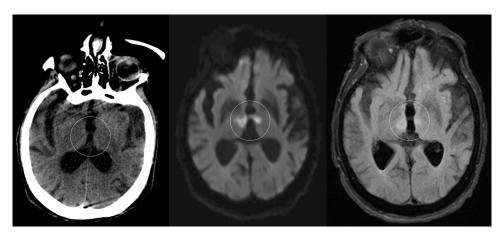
Noncontrast head computed tomography (left) demonstrating no acute thalamic infarct on arrival. Magnetic resonance diffusion weighted imaging (middle) and T2 fluid-attenuated inversion recovery imaging (right) demonstrating signal abnormalities consistent with acute infarct.
